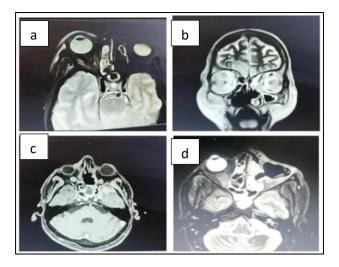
(a-d): MRI shows features of pansinusitis, orbital involvement. Last one showing empty left socket post exenteration requiring revision surgery.
